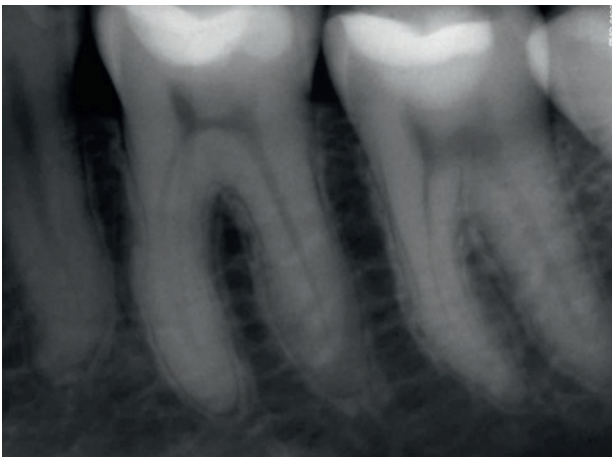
X-Ray at 1 year follow-up.
